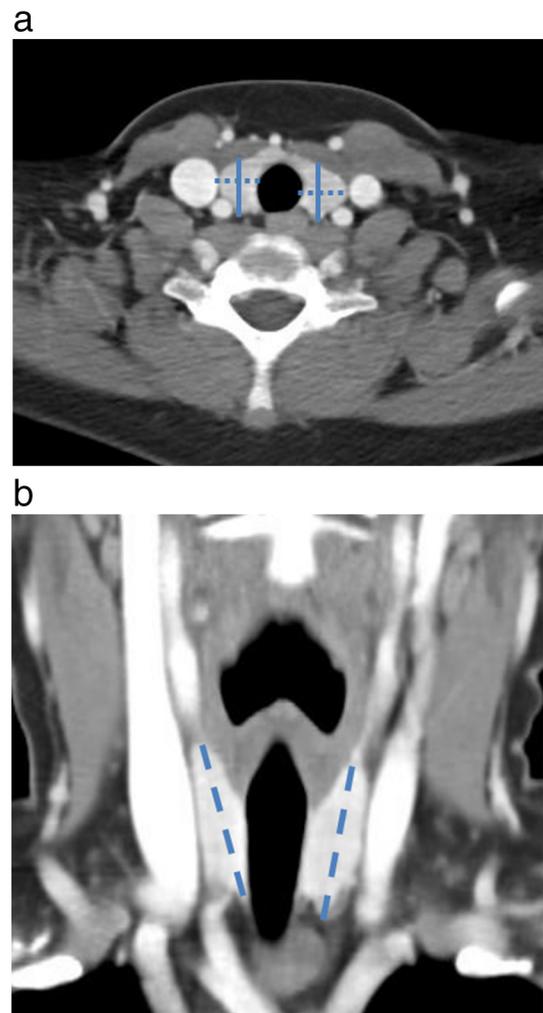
Method of measurement performed on (a) axial and (b) coronal images of contrast enhanced CT. (a) Width: small dotted line, Depth: solid line, (b) Length: large dotted line.
